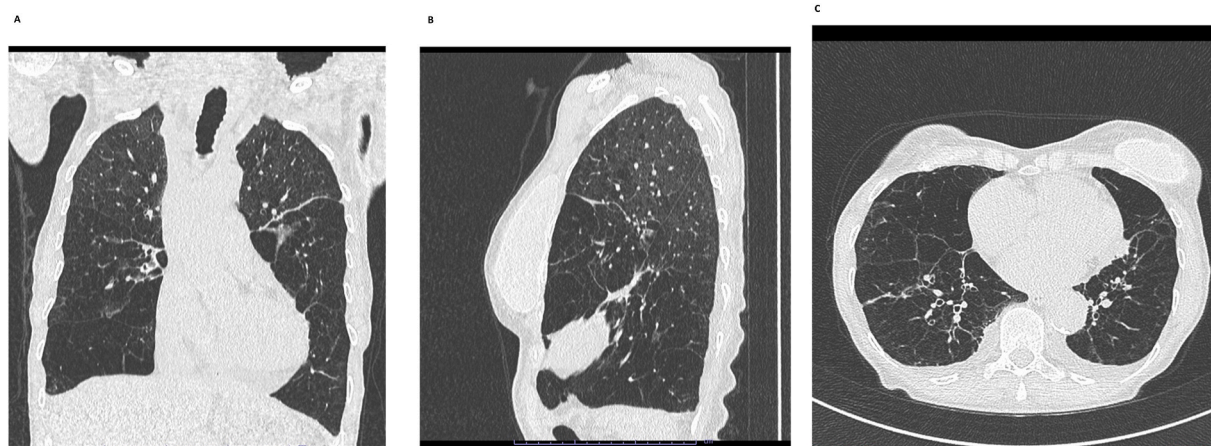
Thin-sliced CT-scan of the lungs in coronal (A), sagittal (B) and axial (C) planes. The predominant finding was severe destructive panlobular emphysema of the inferior lobes.
